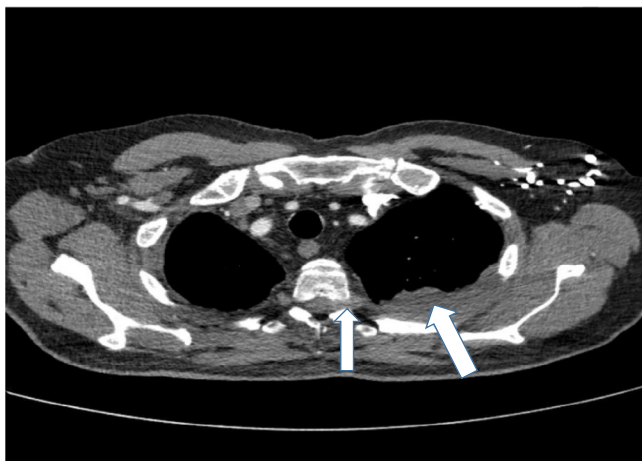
Computed tomography chest, abdomen, and pelvis with intravenous contrast performed as inpatient in June 2016 showed significant size increase of the right pleural disease with disease tapering into the T2/T3 left lateral foramen (blue white arrows).
